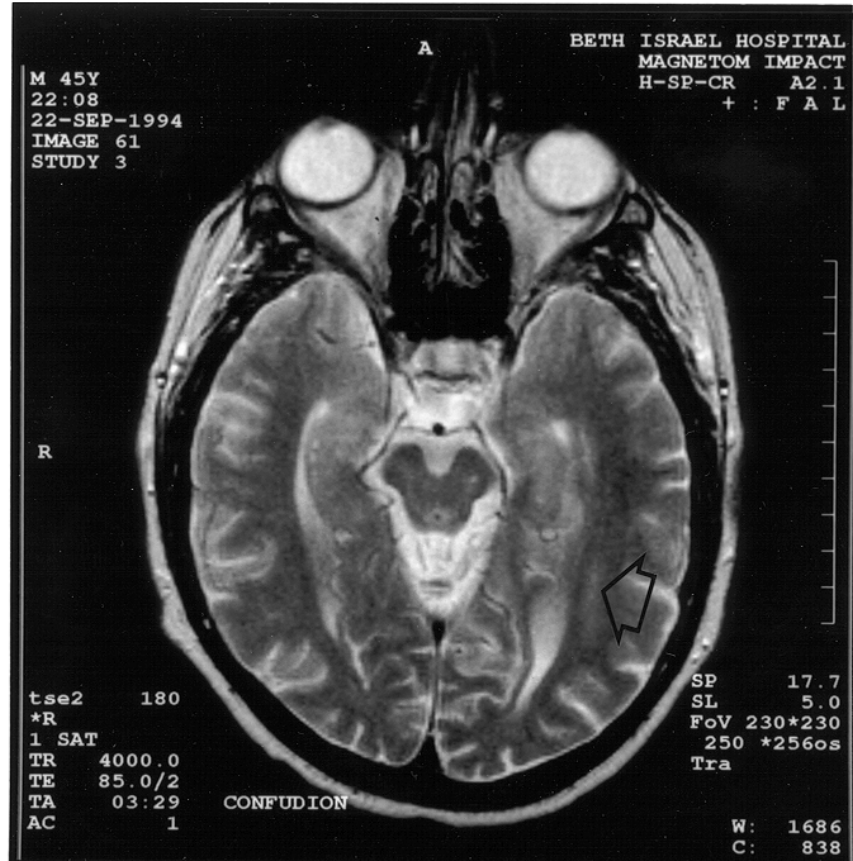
T2-weighted axial MRI image demonstrating a small, linear area of hyperintensity consistent with a subacute stroke (arrow) in the white matter adjacent to Brodmann areas 19 and 37, a localization consistent with the occipitotemporal projection system, the fiber pathway of the ventral visual stream.¹⁰ Location of the stroke was confirmed by lesion analysis as described by Damasio and Damasio.¹³
